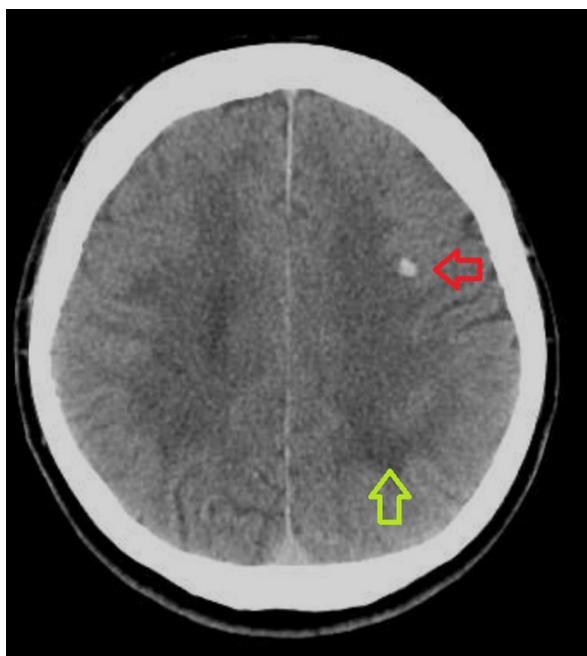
CT image of the head; a red arrow indicates a haemorrhagic focus in the cortical/subcortical area of the left frontal lobe, a green arrow indicates an area of hypodensity in the left parietal lobe
